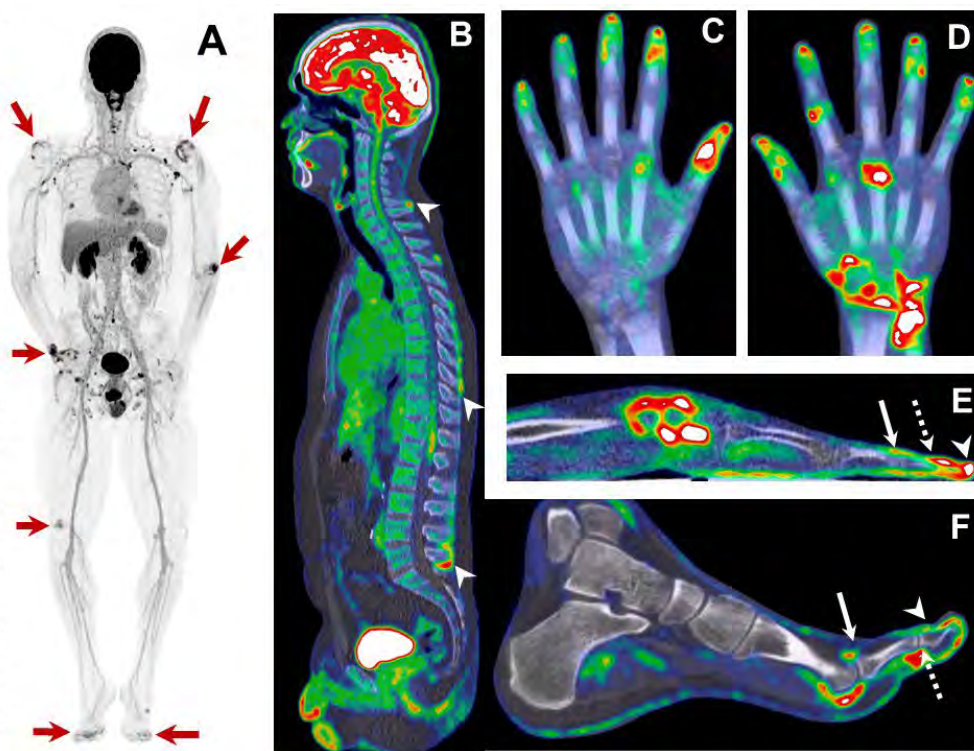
A single Total Body-PET/CT scan can identify the extent and the nature of joint, spine, entheses, and nail involvement in PsA.
